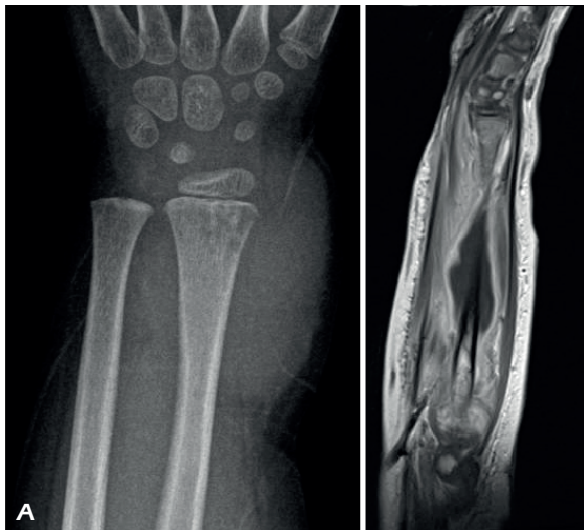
A-B. A 3 and half years old female presented upper right limb swelling, erythema and fever from 3 days, with reduced hand and fingers motility. No significant images were detected on immediate X-rays. MRSA was found on blood culture and antibiotic therapy started with Clarithromycin and Ampicillin. After 9 days radiographs showed osteolysis spots on the distal radius metaphysis. Antibiotic treatment continued but, after an attempt of switching the treatment from intravenous to oral, a soft tissue abscess developed, shows on MRI. So, a new intravenous therapy with Ceftriaxone and Linezolid was prescribed. The 3^o month X-ray shows an evident deviation of the radius diaphysis that improved during the patient growth.
